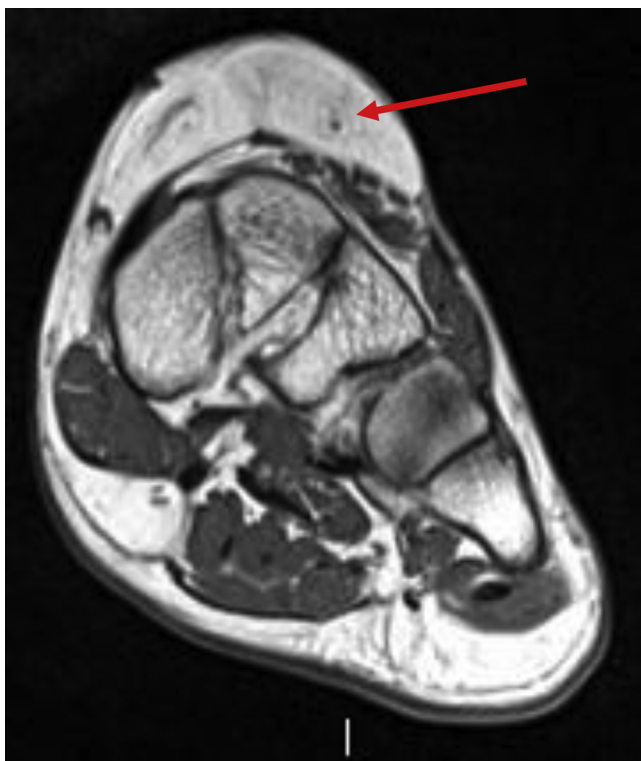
T₁-weighted axial magnetic resonance image (repetition time 666 ms, excitation time 12 ms) showing the mass in the dorsal midfoot that was isointense to subcutaneous fat. Arrow indicates pathognomonic coaxial cable structure, which represents the nerve surrounded by the lesion.
